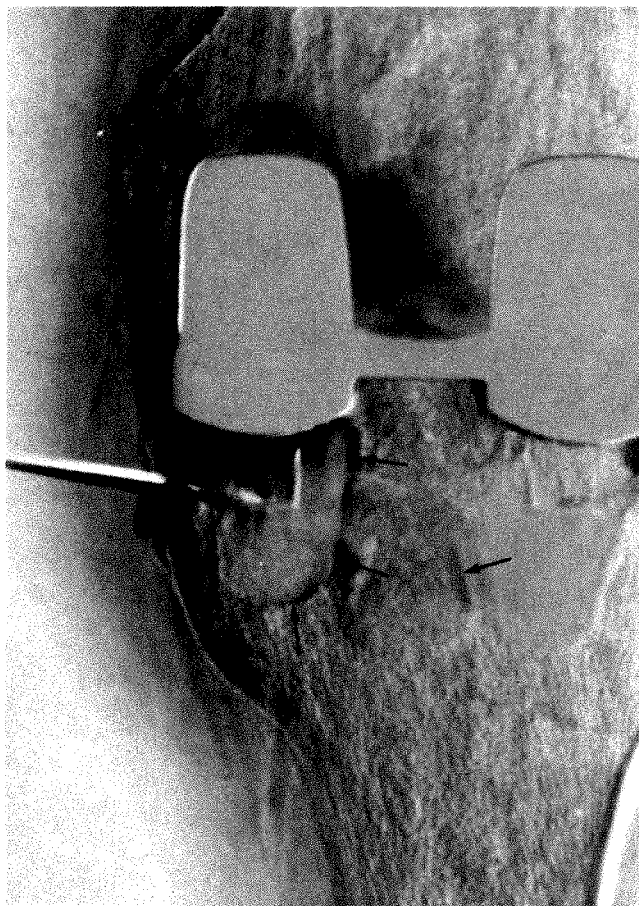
Subtraction radiograph demonstrating contrast at methacrylate-bone interface of tibial component indicating loosening (arrows).
